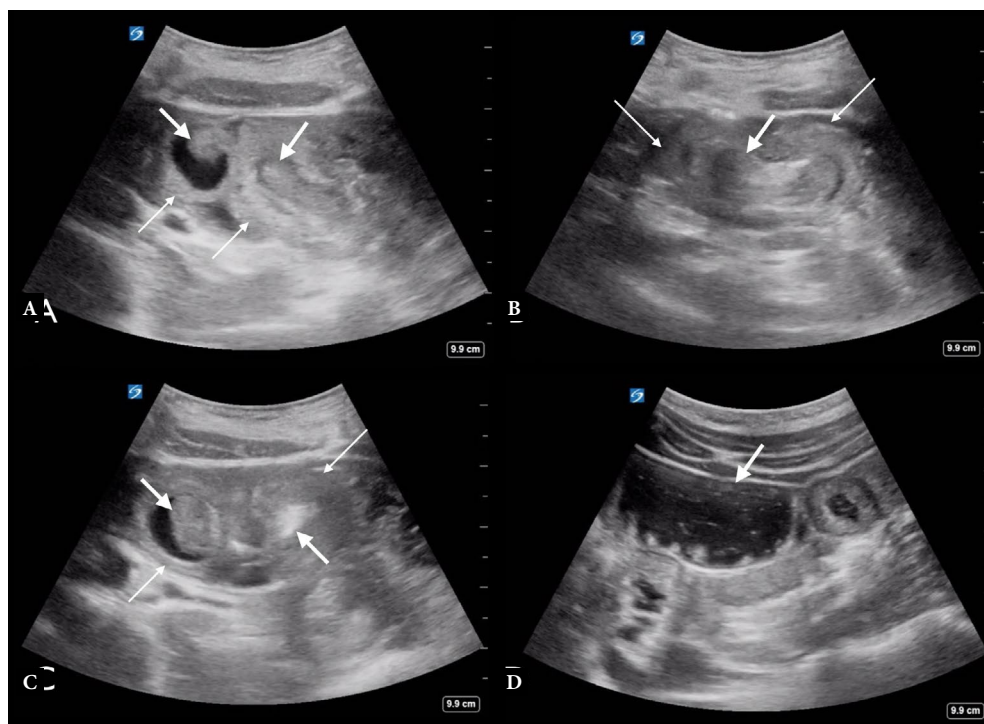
A–C. Showing intussusception site with outer intussusciens (thin arrow) and central intussusceptum (thick arrow). D. with dilated bowel loops (arrow) and early sonographic ileus
